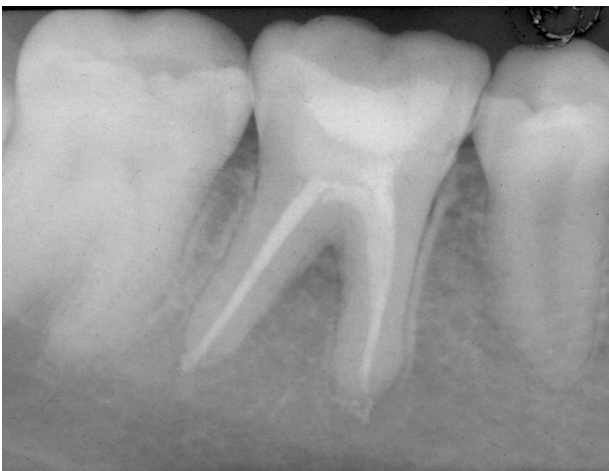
X-ray follow up at 6 months of 4.6. We can notice the successful healing with the disappearance of periapical lesions.
